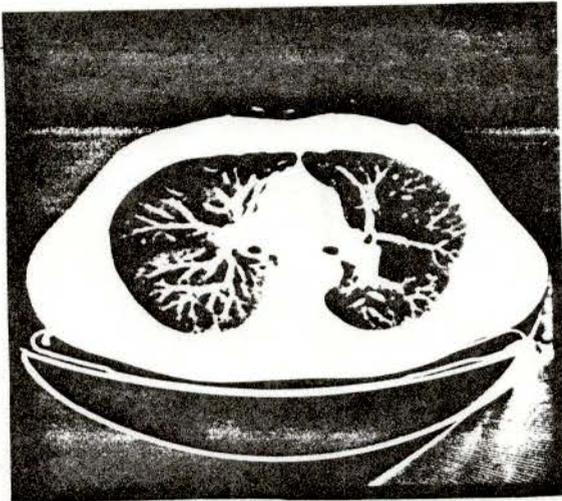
Windowing vs. clipped ahe on various medical images: a) chest CT, b) abdomen CT, c) spine CT.
